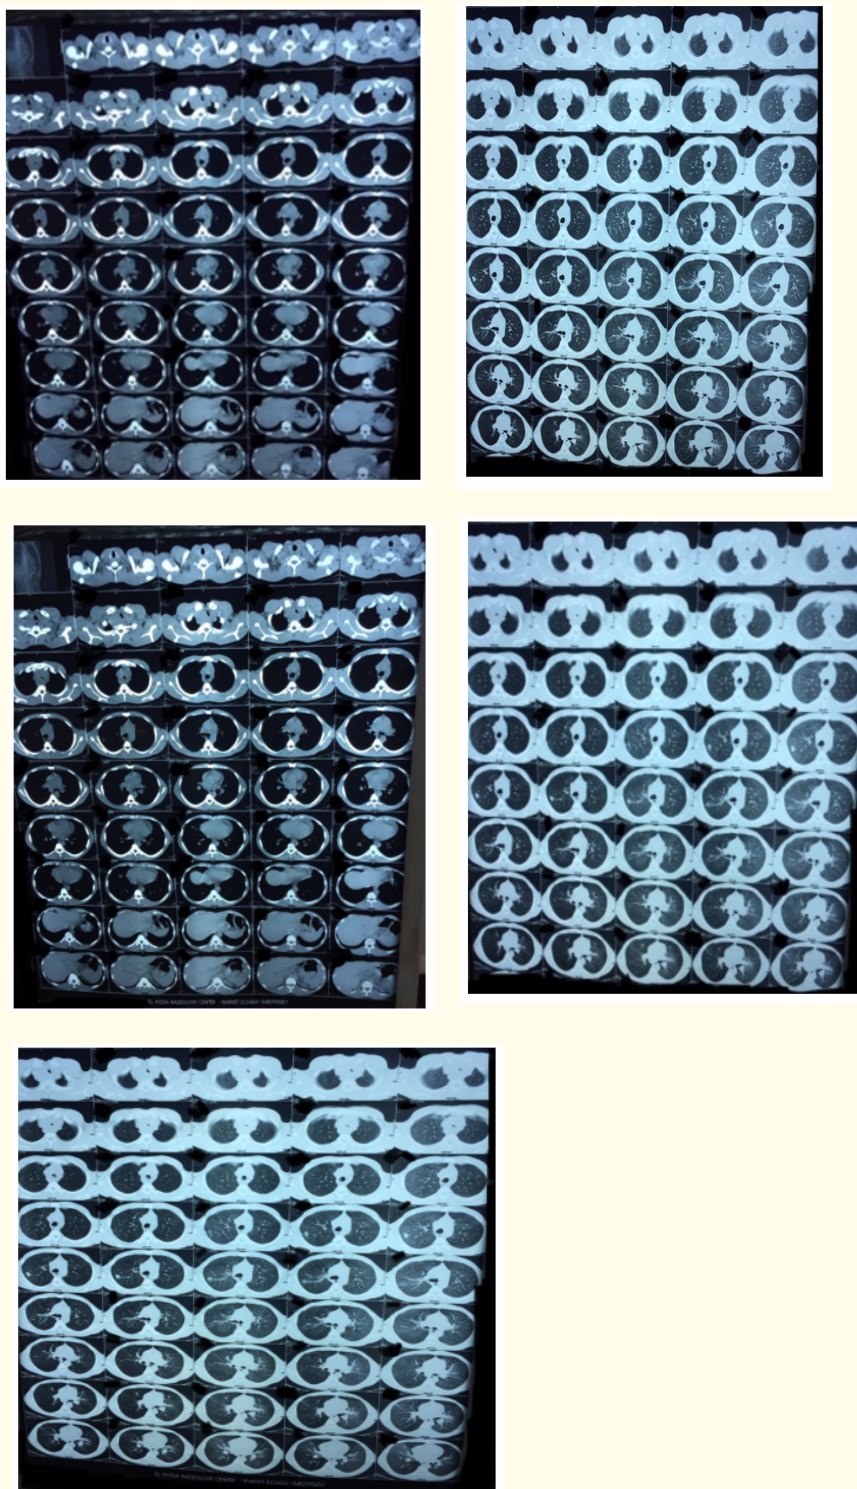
Patient CT showing the lung and mediastinal lesions after initial assessment.
